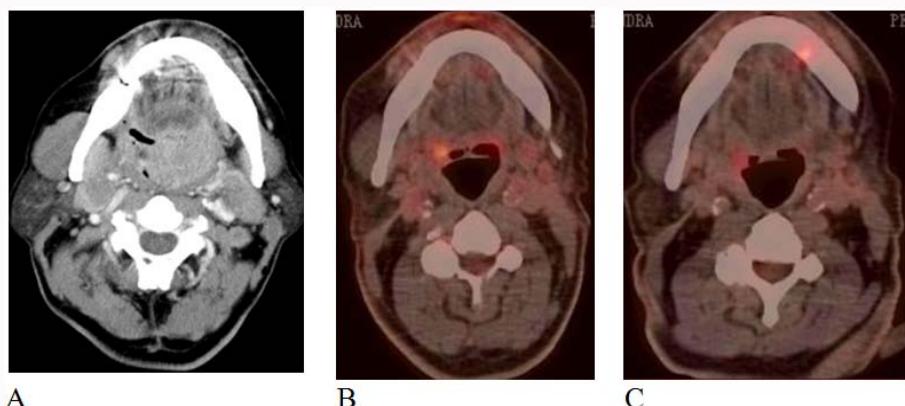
The imaging examination of Case 11. Before treatment, on November 5th, 2016, the tumor of the left tonsil occupied almost the entire pharyngeal cavity (A); the follow-up of PET-CT (B) on October 29th, 2019 and PET-CT (C) on November 29th, 2021 were both showed that the original pharyngeal tumor was no longer present.
